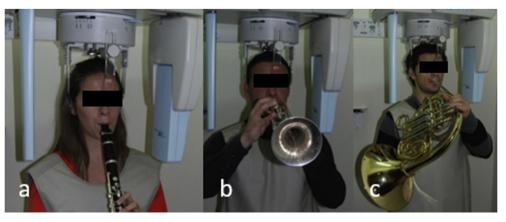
Acquisition of wind instrumentalists lateral cephalometric radiographs.
